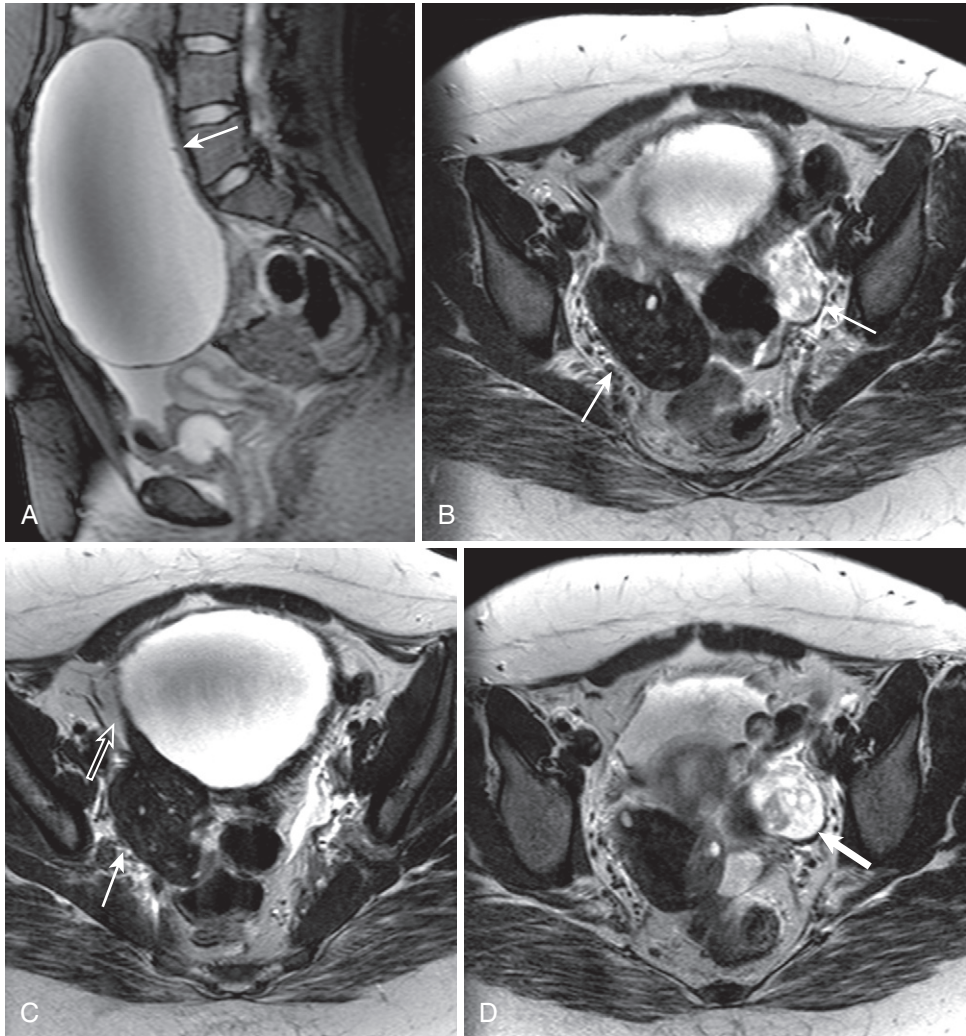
Bilateral ovarian torsion. A, Sagittal T2-weighted fat-suppressed image reveals a large unilocular cystic lesion with a mildly irregular wall thickening (*arrow*) shown to be a serous cystadenoma after surgical resection. B, Axial T2-weighted image shows diffusely abnormal right ovarian hypointensity (*thick arrow*) and diffusely abnormal left ovarian hyperintensity (*thin arrow*). C–E, Axial T2-weighted images through the caudal aspect of the lesion demonstrate the spatial relationship to bilaterally heterogeneously abnormal ovaries (right ovary, *thin arrow* in C and E; left ovary, *thick arrow* in D and E). The diffusely hypointense enlarged right ovary appears directly adherent with a tapering rind of tissue extending along the lateral aspect of the mass (*open arrow* in C), indicating right ovarian origin. The markedly hyperintense left ovary is enlarged to a lesser degree. T1-weighted images without (E) and with (F) fat suppression reveal ovarian hypointensity, particularly on the left (right ovary, *thin arrow* in E and F; left ovary, *thick arrow* in E and F), with a minimal peripheral rim of hyperintensity seen to better advantage on the fat-suppressed image (*open arrow* in F). G, Lack of enhancement is more definitively identified (*arrow*). H, Mild relative ovarian enhancement (*thick arrow*) and a focal serpiginous lesion (*open arrow*) likely representing the sequela of an involuted corpus luteal cyst are discernible. Surgical resection confirmed right ovarian hemorrhagic ischemia; the left ovary was described as edematous, but not ischemic—probably the effects of intermittent low-grade ischemia/partial torsion.
